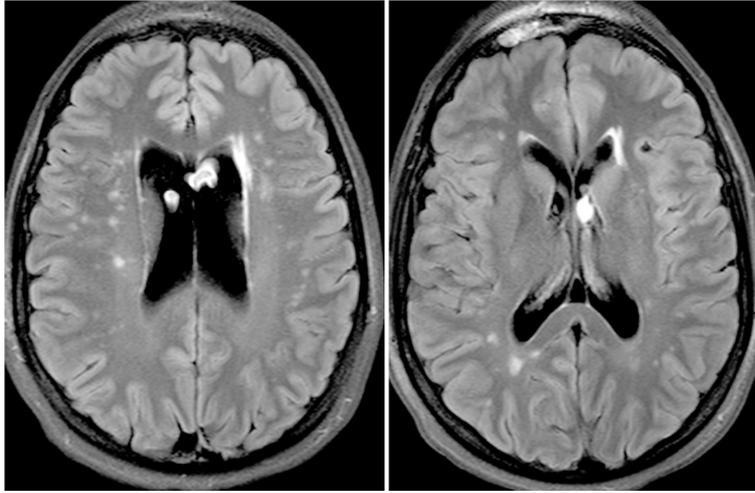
Brain MRI of a 38 year old revealing multiple focal hyperintensities.
